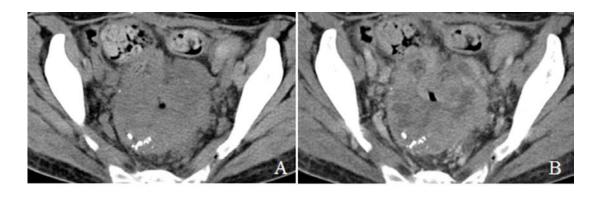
Rectal axial computed tomography: non-contrast (A) and contrast-enhanced (B).
